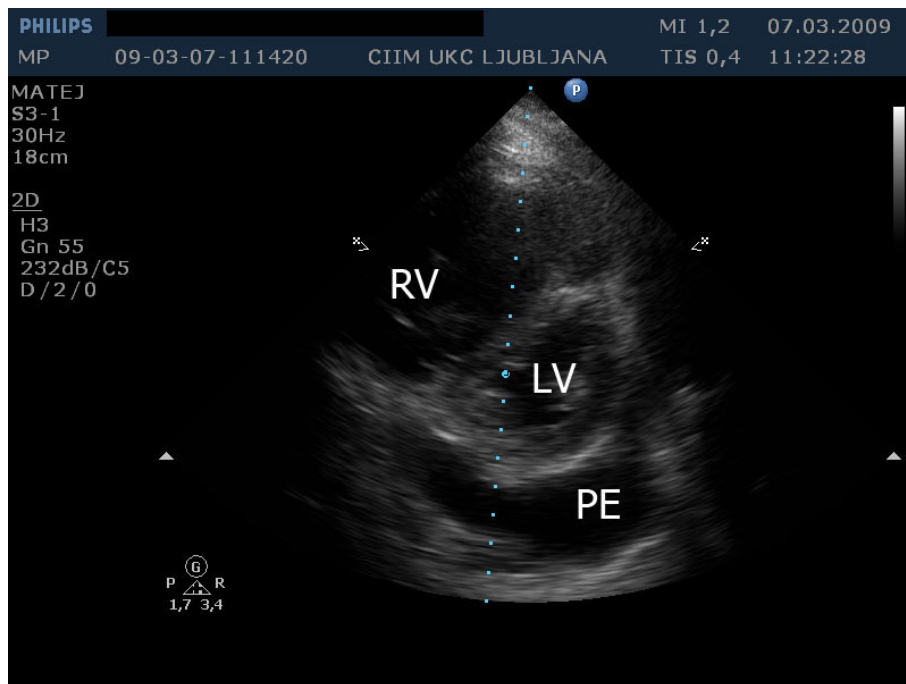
Transthoracic echocardiography from short-axis plane at the papillary muscle level shows enlarged right ventricle (RV) with paradoxical movement of intraventricular septum. Left ventricle is compressed by RV and pericardial effusion (PE).
